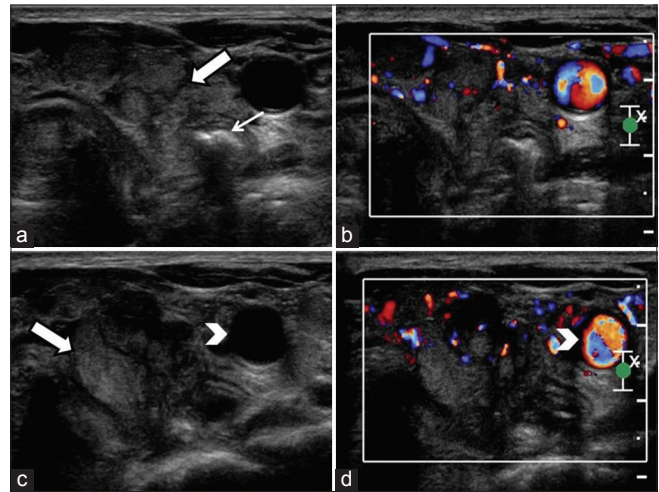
Transverse view of an ultrasound of the left lower pole of the thyroid gland revealed several solid heterogeneous nodules (a and c) (white arrow), some with hypoechoic areas and coarse calcification (thin white arrow) within, and increased internal vascularity in (b and d). There was encasement of the left common carotid artery (arrowhead) at this level; however, the left common carotid artery was patent
